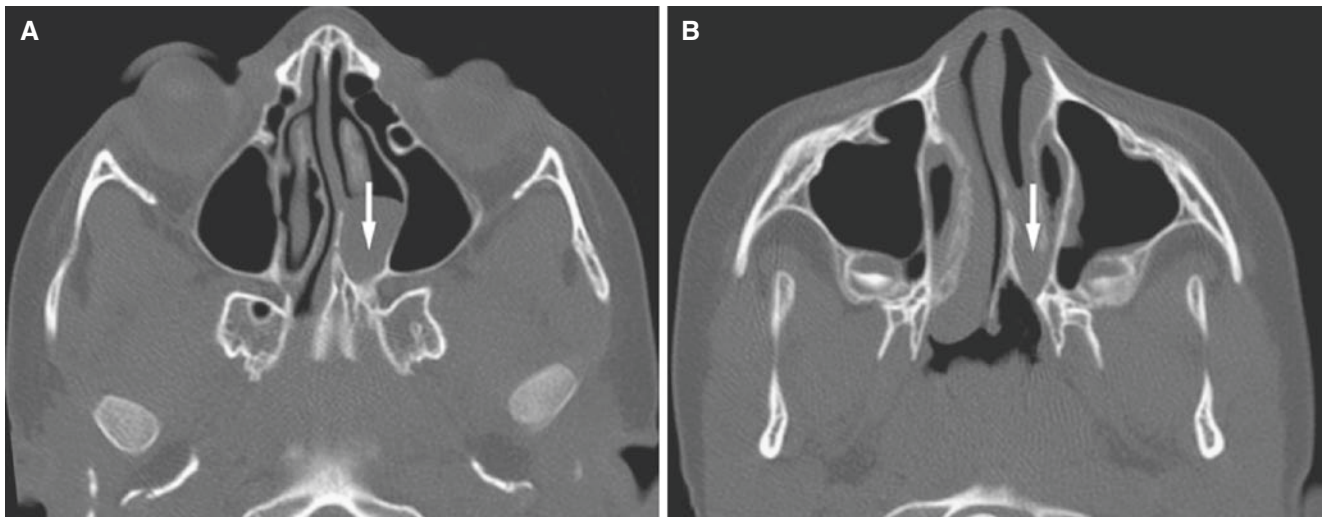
Choanal atresia; 7-year-old female presented with chronic left nasal obstruction. (A) Axial CT image shows bony plate between the posterior vomer and posterior lateral nasal wall (arrow) and probable
